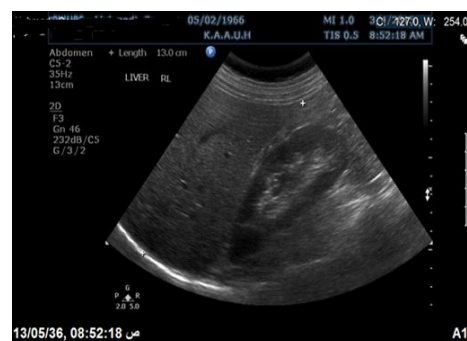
Sonogram of normal liver to measurement liver size in the MCL during inspiration in supine position.
